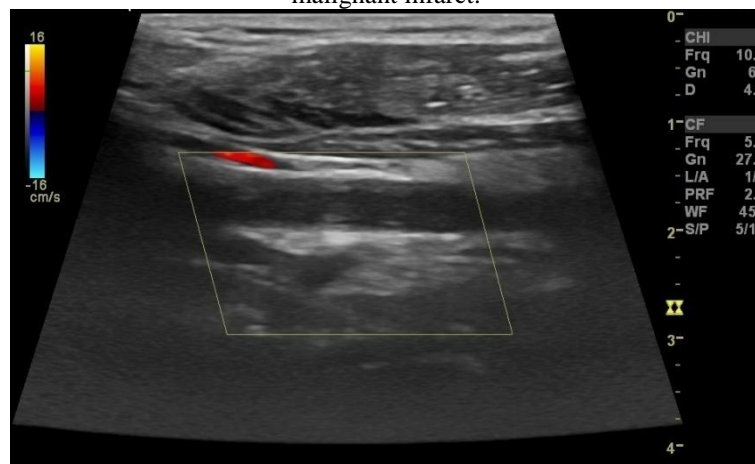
On carotid Doppler evaluation, complete occlusion of the ipsilateral common and internal carotid artery was noted with no obvious color flow.
